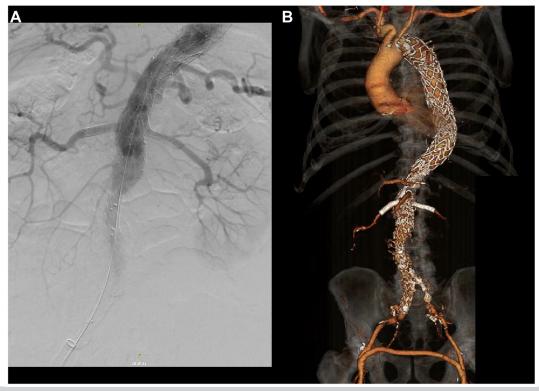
A, Completion angiography after placement of four-vessel inner-branched device and aorto-uni-iliac component. B, Three-dimensional volume rendering of 3-month postoperative computed tomography scan showing patency of all four branch vessels and no further perfusion of the aneurysm sac or false lumen.
